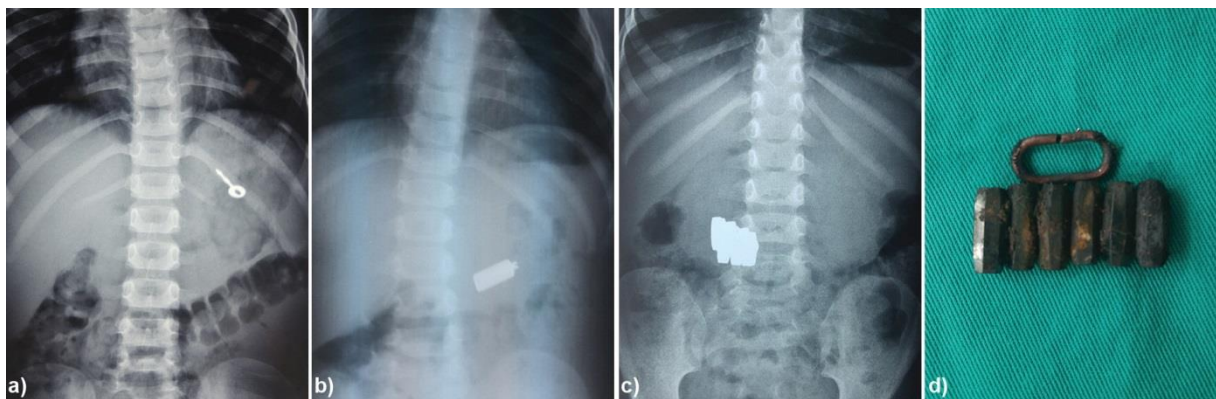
Gastrointestinal foreign bodies on radiographs and after removal: a) metal key in stomach, b) zipper puller in stomach, c) magnets in stomach, d) magnets and ring after endoscopic and surgical removal
